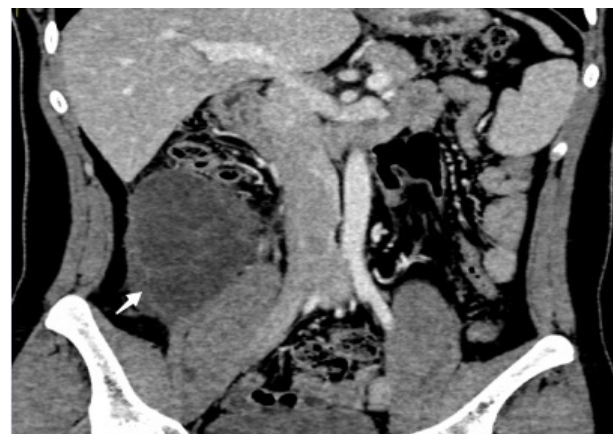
The arterial phase of the enhanced scan shows a cystic mass in the ileocecal paracolic groove, approximately 7.4 cm × 6.4 cm × 13.3 cm in size, with enhancement visible at the edge and separation of the lesion, and a CT value of 25 HU
